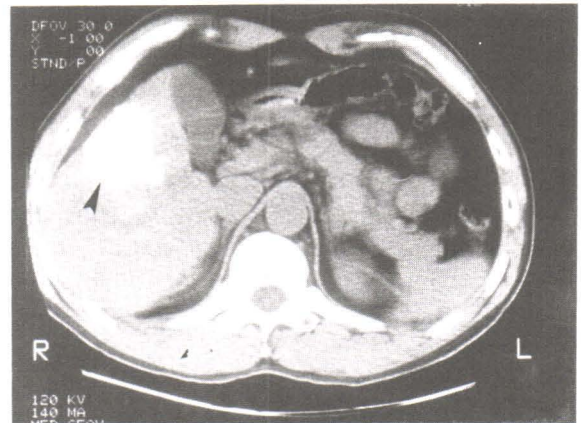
Same case as in Figure 3, lipiodol CT scan following repeated TOCE shows a complete opacification of HCC by lipiodol (arrow) representing necrosis of the tumor.
